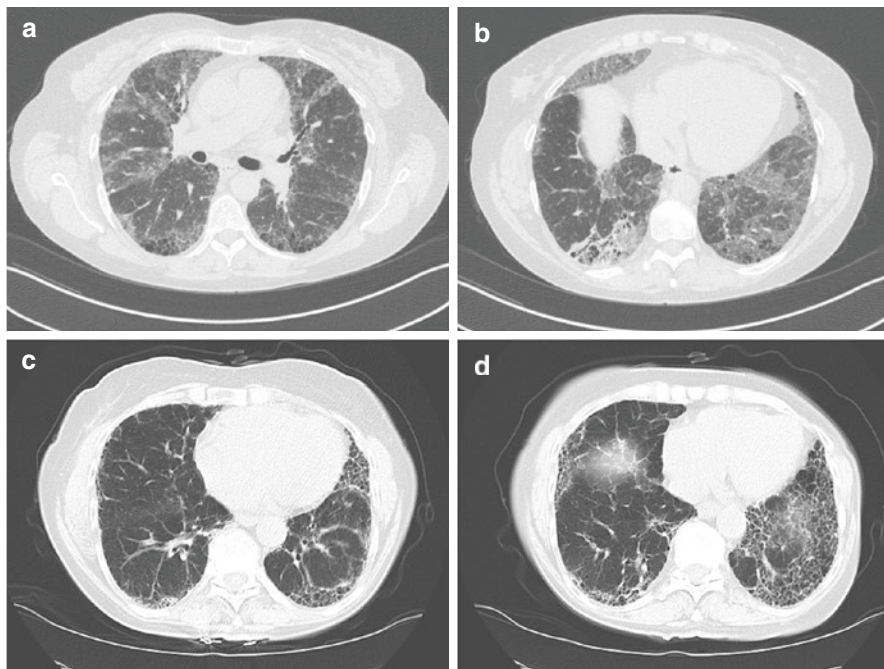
Interstitial lung disease associated with MPO-ANCA. (Panel a and b) Chest computed tomography cuts from a 49-year-old patient with a 4-year history of MPO-ANCA-positive interstitial lung disease showing bilateral diffuse ground-glass infiltrates in the upper and lower lobes. Cystic scarring is also seen in the lower lobes posteriorly with some traction bronchiectases. These features are consistent with nonspecific interstitial pneumonitis. The cystic fibrotic lesions are too large to be called honeycombing. Two years following the diagnosis of interstitial lung disease, the patient developed mononeuritis multiplex and glomerulonephritis despite receiving low-dose prednisone and mycophenolate mofetil. (Panel c and d). Chest computed tomography cuts obtained from a 76-year-old lady who presented with cough and shortness of breath, an elevated sedimentation rate and C-reactive protein, and a positive MPO-ANCA test result, but without any other organ symptomatology. The images show fibrotic changes, including honeycombing and traction bronchiectases with a lower lung predominance and peripheral distribution and complete absence of ground-glass infiltrates; these features are typical for usual interstitial pneumonia (UIP). Review of old chest X-rays revealed the presence of fibrotic changes in the lower lungs dating back 4 years. She never developed any signs or symptoms of MPA, and died 5 years later of an “acute exacerbation of IPF”
